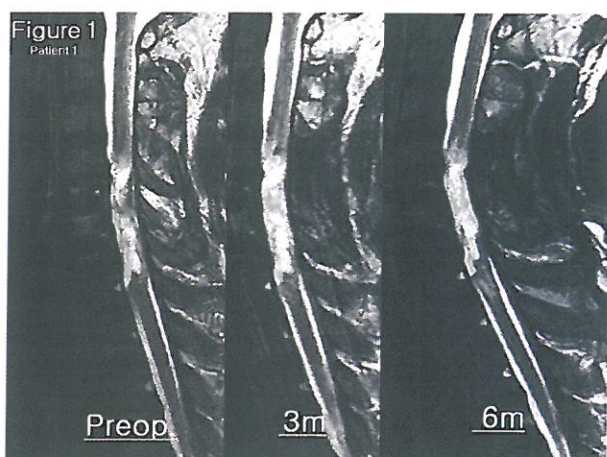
In Patient 1, T2 weighted image of the follow-up MRI showed disappearance of low signal intensity in contusion site and appearance of high signal intensity at the distal part of contusion site.
